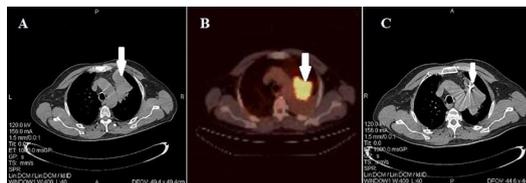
(A) Chest CT scan. Tumour mass within atelectasis (arrow). (B) Positron emission tomography/CT scan. Metabolic active focus within atelectasis (arrow). (C) Chest CT scan. Biopsy needle placed into metabolic active area (arrow).
